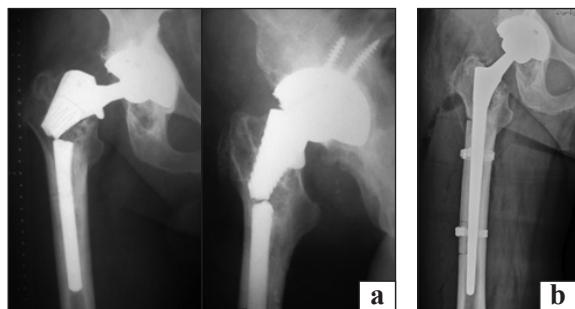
Patient S. Radiographs “before” and “after” surgical interventions: fracture of the endoprosthesis stem (a); after revision arthroplasty, removal of the broken stem and its replacement (b)
